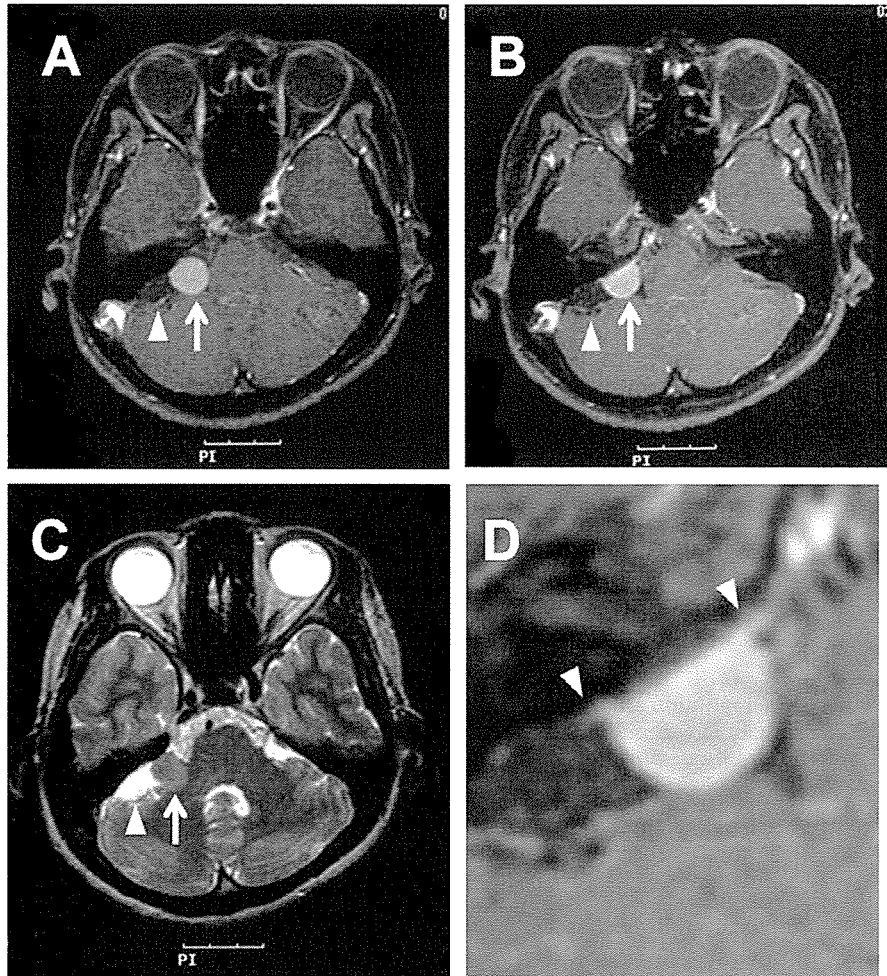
MRI findings of the tumor. (A, B) Gadolinium-enhanced T1-weighted images at different levels. (C) T2-weighted image. Arrows indicate the solid part and arrowheads indicate the cystic part of the tumor. (D) Arrowheads indicate the enhanced dura mater at the attachment to the base of tumor ('dural tail sign').
